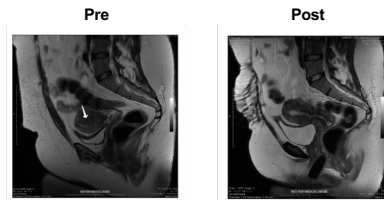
Baseline premenstrual MRI (T2) in the sagittal plane shows normal-appearing endometrium.
